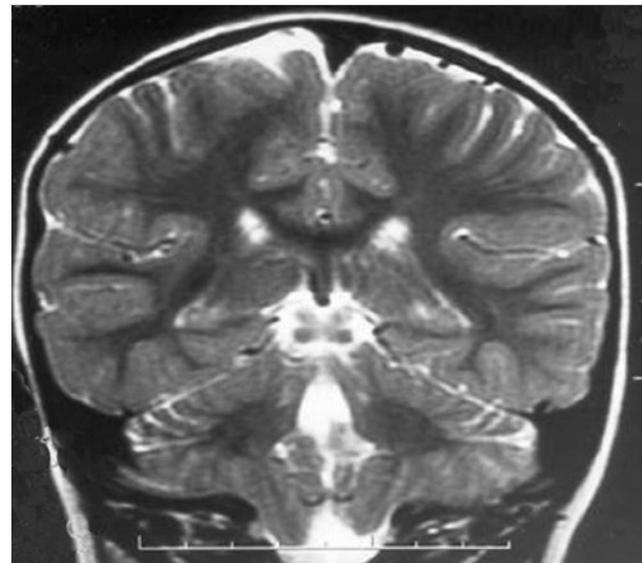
Coronal magnetic resonance image demonstrating a Chiari 1 malformation. Note the asymmetry of the descended cerebellar tonsils.
